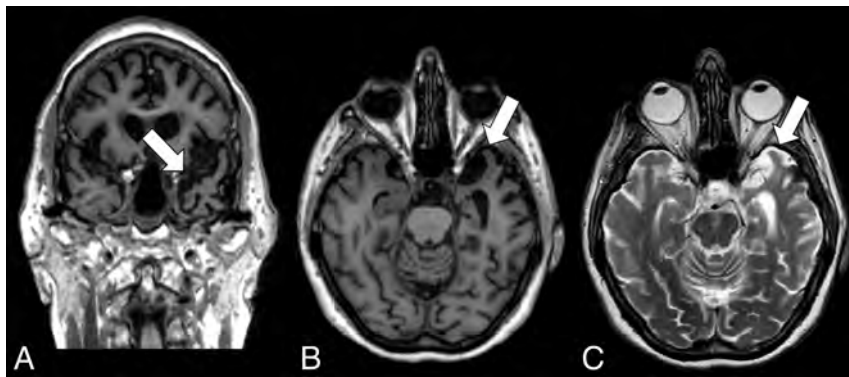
Coronal T1-weighted MR imaging (A), axial T1-weighted MR imaging (B), and axial T2-weighted MR imaging (C) in a right-handed individual with impaired single-word comprehension demonstrate marked asymmetric atrophy of the anterior left temporal lobe (white arrows, A–C), suspicious for svPPA.
